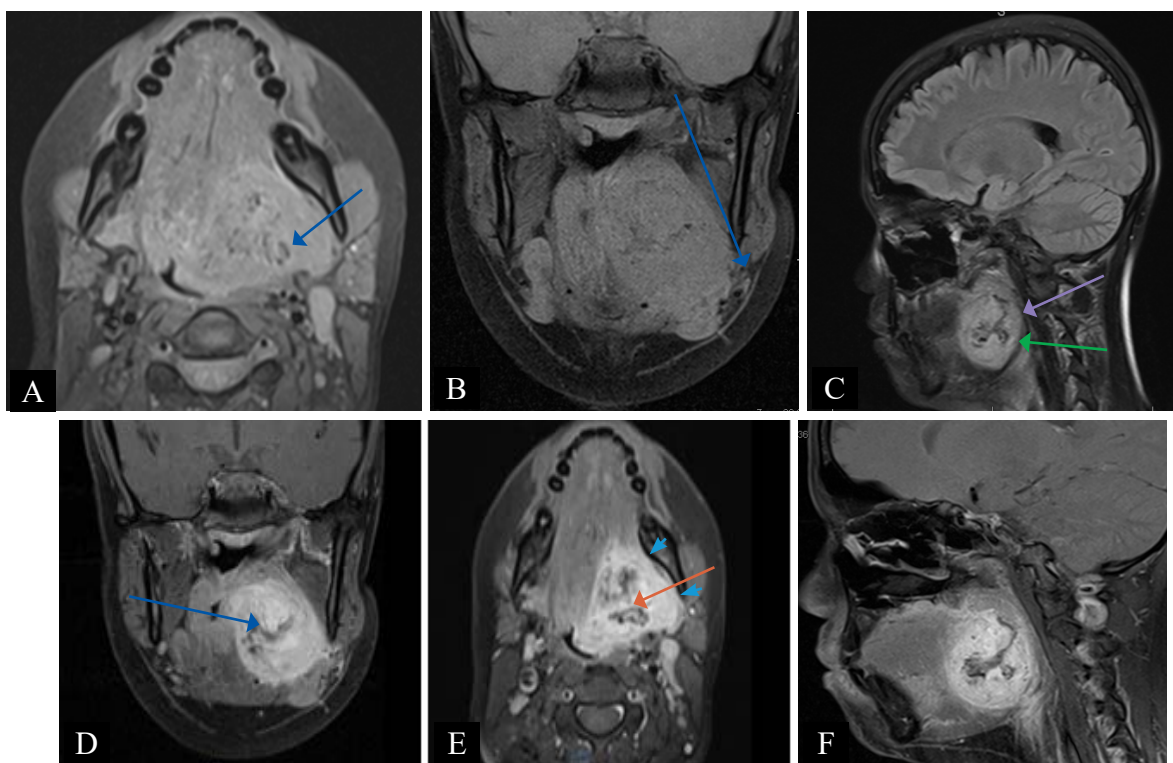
A – Axial pre-contrast fat saturated T1 weighted image MRI scan of the neck showing a well-defined centred mass (blue arrow) within left tongue base that is isointense to muscle. B – Coronal pre-contrast fat saturated T1 weighted image MRI showing mass abutting the deep lobe of the left parotid gland. C – Sagittal FLAIR T2 weighted image MRI showing a hyperintense mass with no plane of cleavage between mass and left posterior intrinsic muscles of the tongue. Multiple ring-like lesions are seen in the mass – fascicular sign (purple arrow). Target sign is a central area of low intensity surrounded by a T2 hyperintense rim (green arrow). D-F – T1 weighted MRI neck images post-gadolinium contrast in three planes: coronal (D), axial (E) and sagittal (F). Lingual schwannoma of the base of tongue (blue arrows) is largely solid and vascular with brisk enhancement and central necrosis (orange arrow). The fat split sign is demonstrated by the blue arrowhead. Sagittal post-contrast T1 image of the neck (F) shows no involvement of the prevertebral space.
